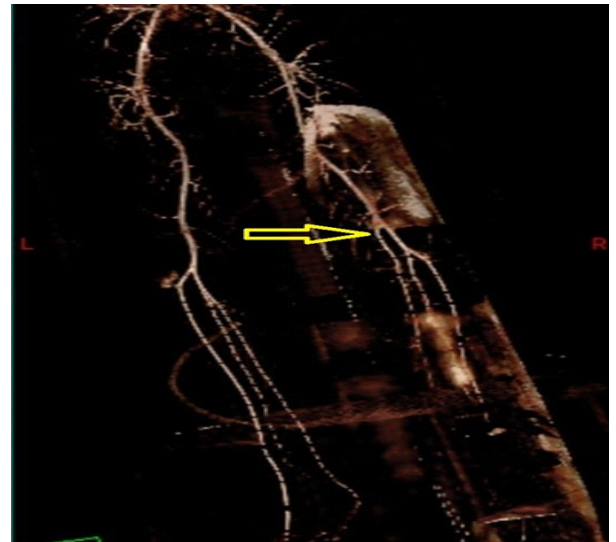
CT angiogram showing early branching of the popliteal artery (Arrow)
